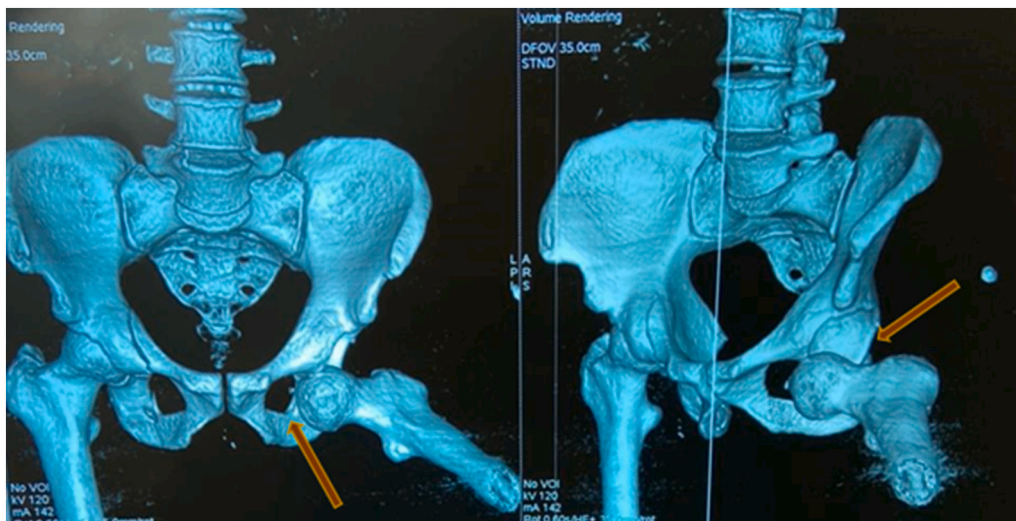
Case 1: CT scan of the pelvis with 3D reconstruction showing vacuity of the acetabulum with the femoral head next to the obturator foramen.
